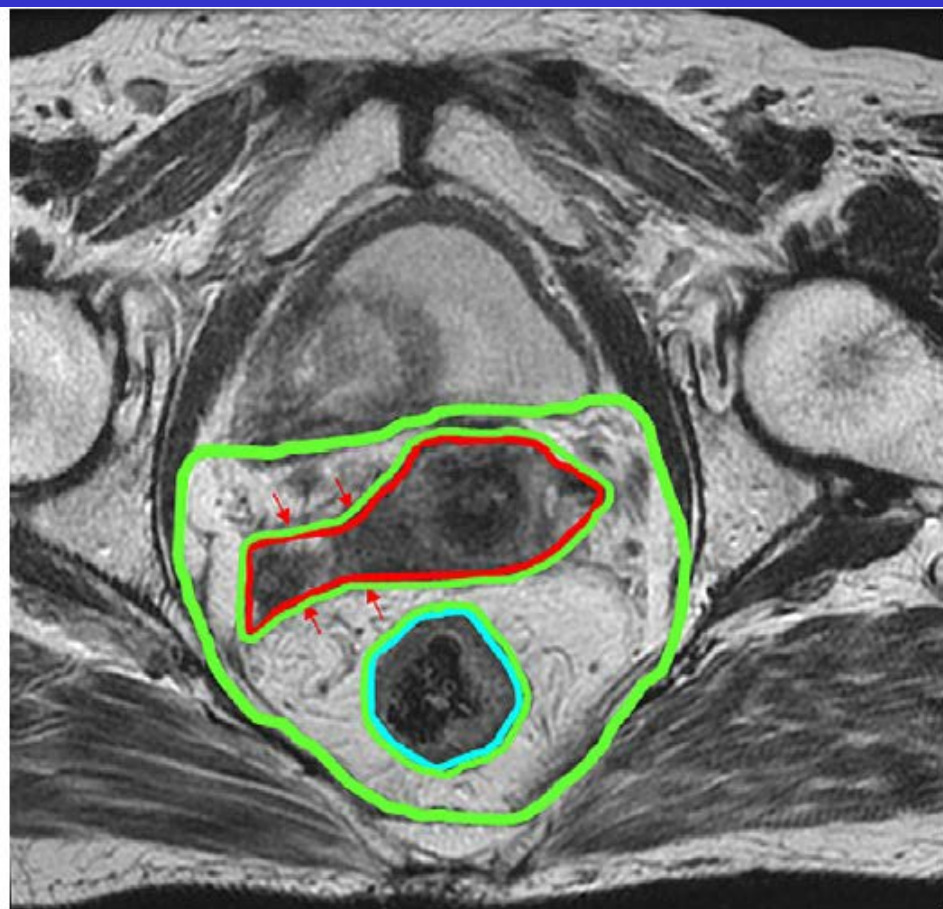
Axial T<sub>2</sub>-weighted MR image of a patient showing the GTV (red contour), modified parametrium (green), and rectum (light blue); red arrows indicate right proximal uterosacral ligament invasion.
